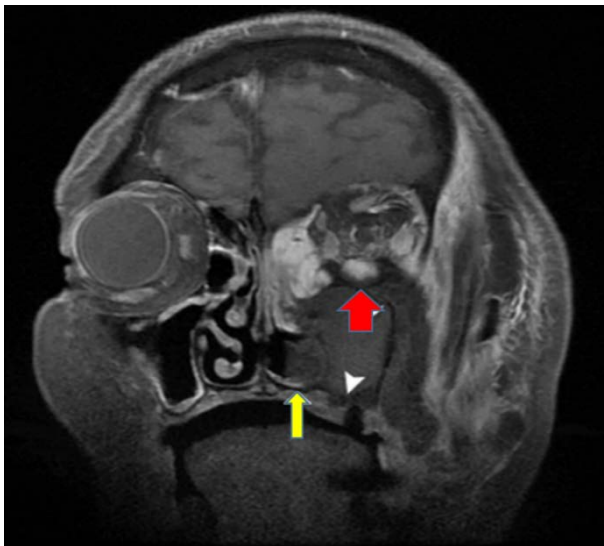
Acute invasive fungal rhinosinusitis. MRI scan (T1 mode with contrast enhancement and suppression of adipose tissue). On the coronal section, there is a darkening of the left maxillary and ethmoid sinuses with a reduced density of the middle and lower turbinates (yellow arrow), loss of contrast enhancement of the maxillary sinus mucosa (white arrow) and lower rectus muscle (red arrow).
